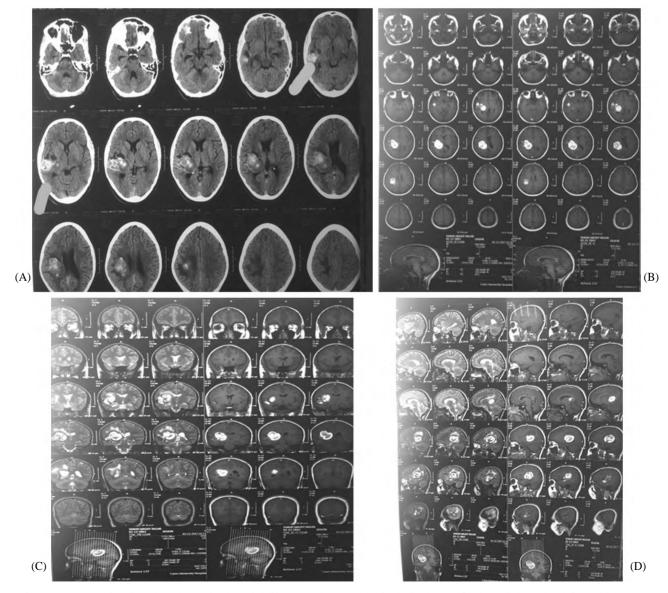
Preoperative CT (a) and MRI in the axial (b), coronal (c) and sagittal (d) planes of a deep right parietal CM with recent hemorrhage in a 16 year old male patient.
